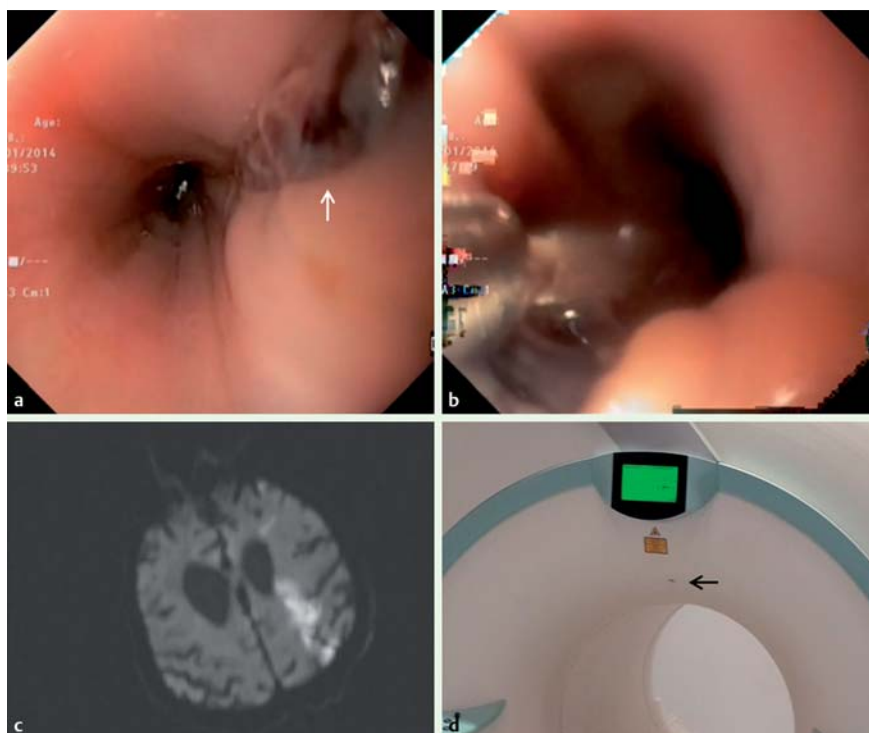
An 82-year-old patient underwent hemoclip application for hemostasis, with lethal consequences at subsequent magnetic resonance imaging (MRI). a The linear laceration in the esophageal wall seen during upper endoscopy. b Hemoclip application for hemostasis. c Diffusion-weighted MRI section at $b = 1000 \text{ s/mm}^2$ demonstrated high signal intensity in the left parietal lobe (which has low mean apparent diffusion coefficient values – not shown), consistent with cytotoxic edema due to acute infarction. d A hemoclip (arrow) in the MRI scanner.
